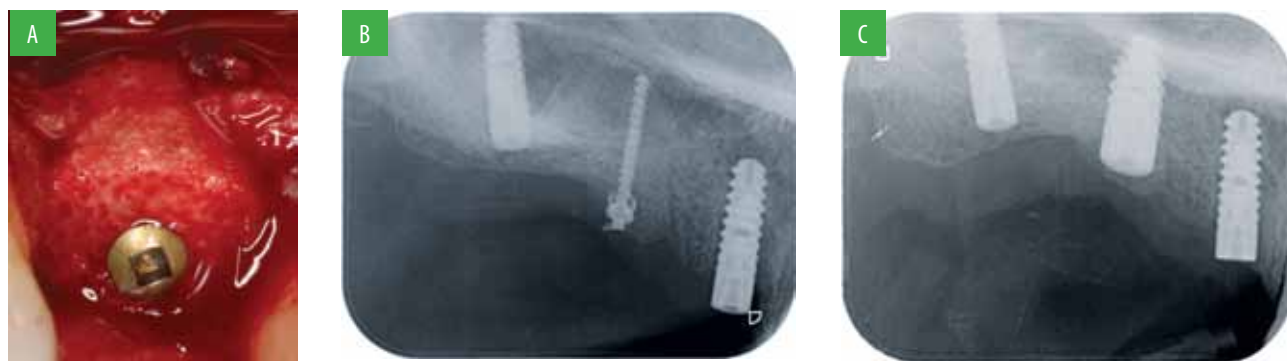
A. Placement and stabilization of C-Block; B. Radiographic examination of the bone block; C. Radiographic examination of the implant.
